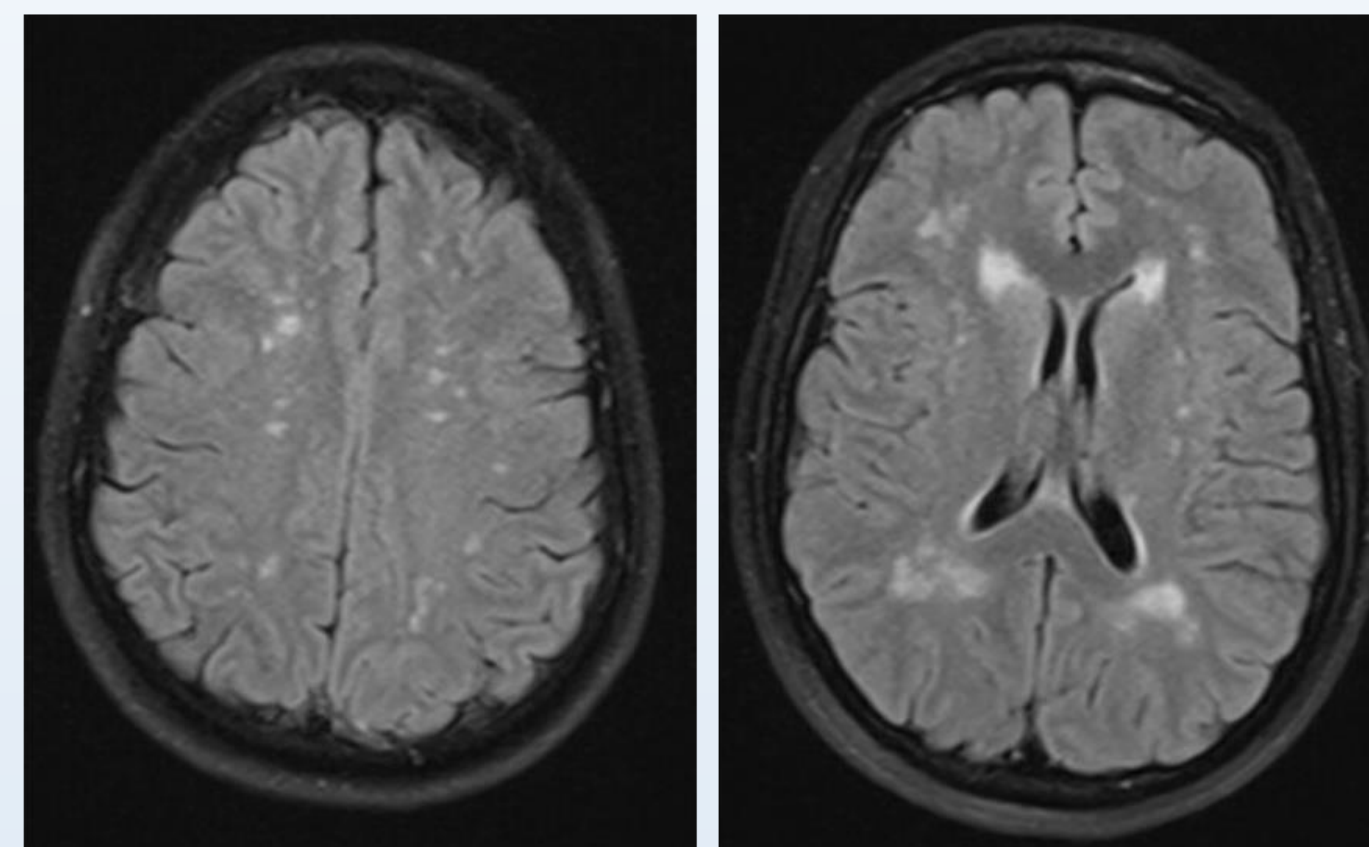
Comparison of 2014 (top) and 2020 (bottom) brain MRIs, demonstrating progression of FLAIR hyperintense foci in subcortical and periventricular white matter
